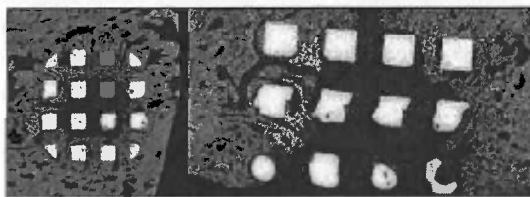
Bone ingrowth of scaffold in minipig mandibula as measured by μ CT providing a resolution of 30 μ m.
